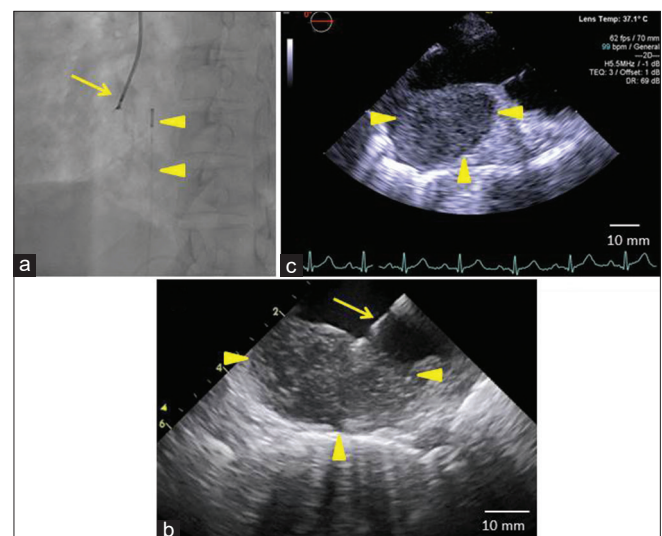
Images of intracardiac mass. (a) Catheter for intracardiac echocardiography (arrowhead) and cardiac biptome (arrow), (c) transesophageal echocardiography shows a hypodense mass attached to the anterior atrial free wall (arrowhead), (b) biptome (arrow) contacting the tumor (arrowhead) visualized on intracardiac echocardiography
